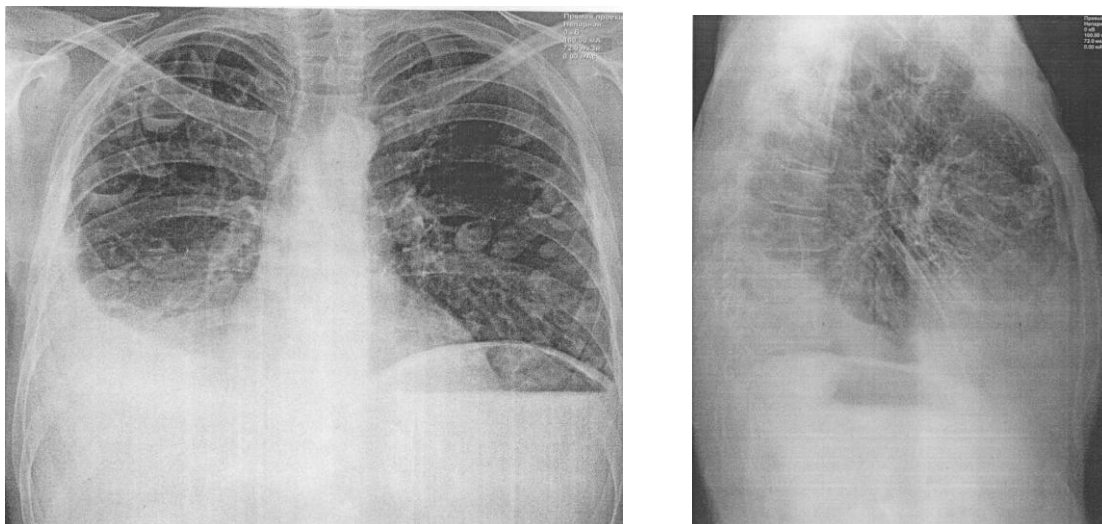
Chest X-ray in the frontal and lateral projections
